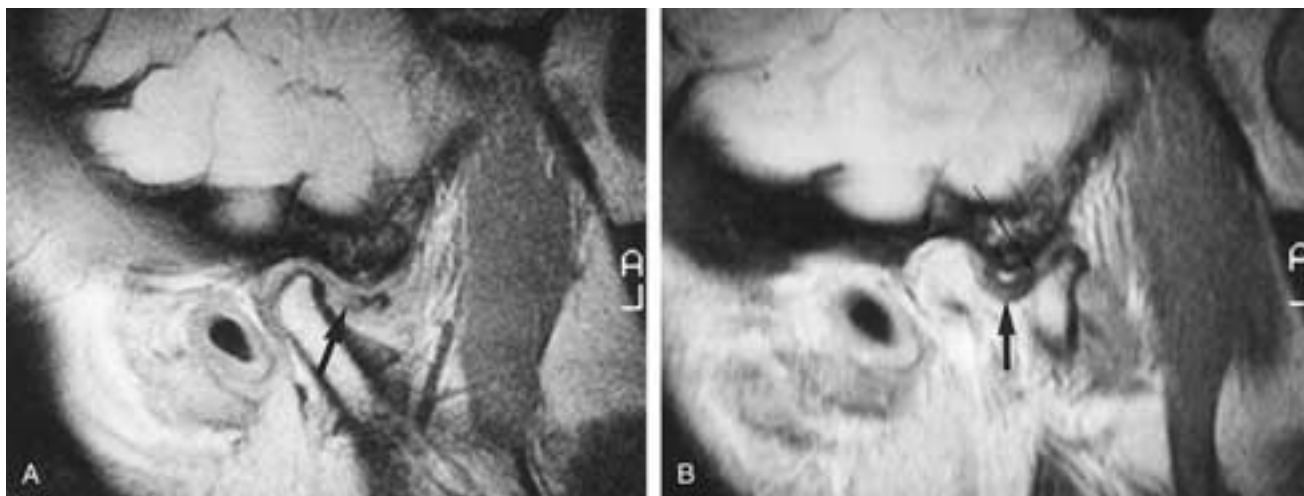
Subluxation in front of the disk. A, Proton density sagittal MR image shows the disk (*arrow*) anterior to the condyle. The disk is deformed. B, On maximal mouth opening the condyle is in front of the disk (*arrow*), and the disk is preventing the condyle from reverting back into the glenoid fossa. The long arrow indicates the anterior edge of the disk.
